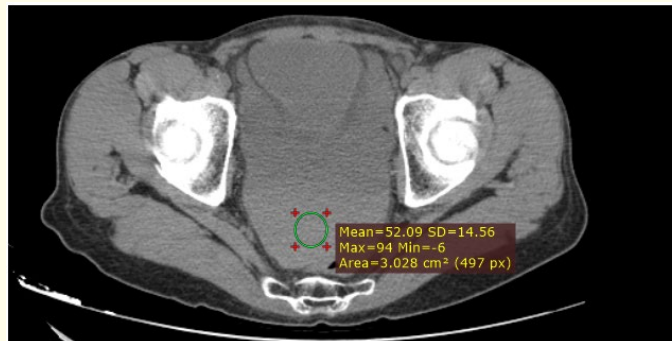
Axial section of an abdominal CT scan without contrast injection showing a large pelvic fluid accumulation with hematoma density.
